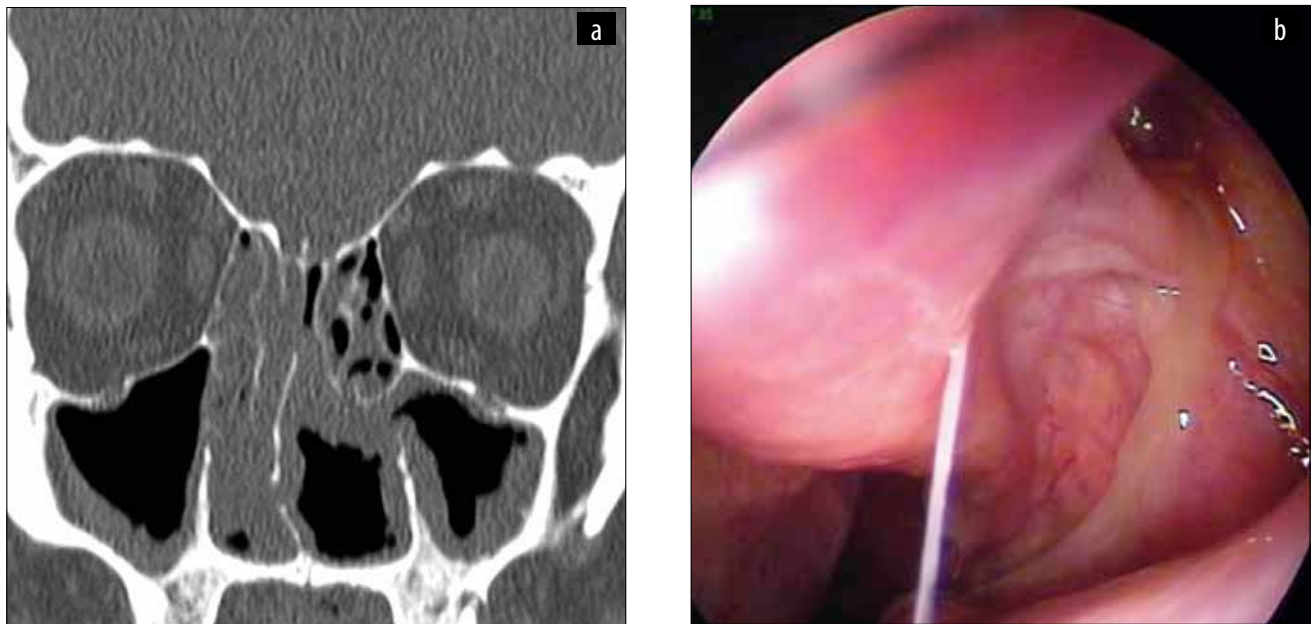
Incomplete ethmoidectomy – a. Cranio-facial CT scan, coronal slice; b. Nasal endoscopic examination – adherent secretion running out from the left middle meatus.
